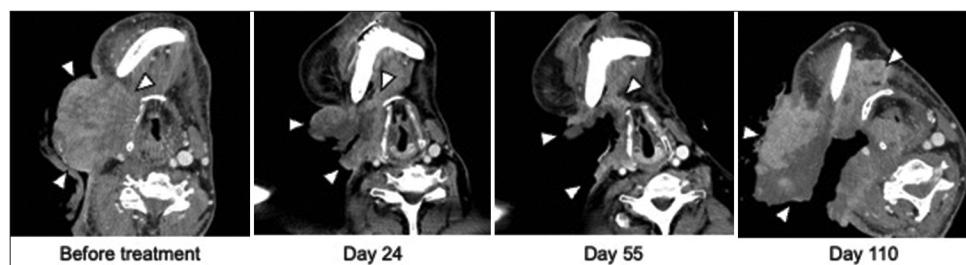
The treatment response of the right neck tumor. Serial contrast-enhanced CT images showed a huge protruding tumor at the right upper neck, with an invasion of the thyroid cartilage. After taking alpelisib, the tumor became smaller in the following image (day 24 and day 55). However, 10 days after discontinuing alpelisib, the neck tumor enlarged in a follow-up CT scan (day 110). CT: Computed tomography
